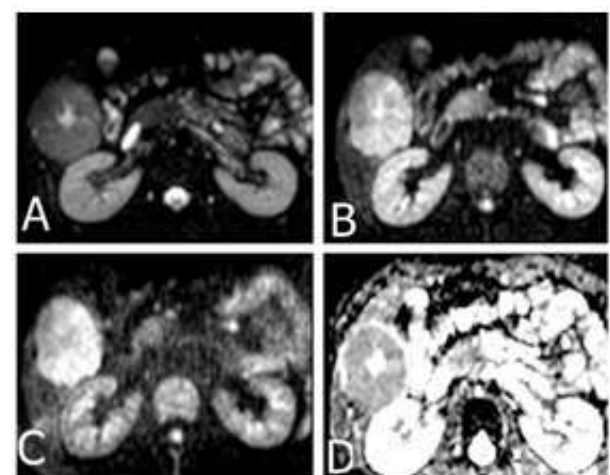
This figures showed that the diffusion weighted MRI of 50 years old female patient with FNH, DWI at b0 (A), DWI at b500 (B), DWI at b1000 (C). ROI is located peripherally in the lesion since central part represent vascular scar tissue. Mean ADC value at b1000 (B) = $1.3 \text{ A}3 \text{ mm}^2/\text{s}$. though lesion is hyperintense at DWI, it shows high ADC value.
